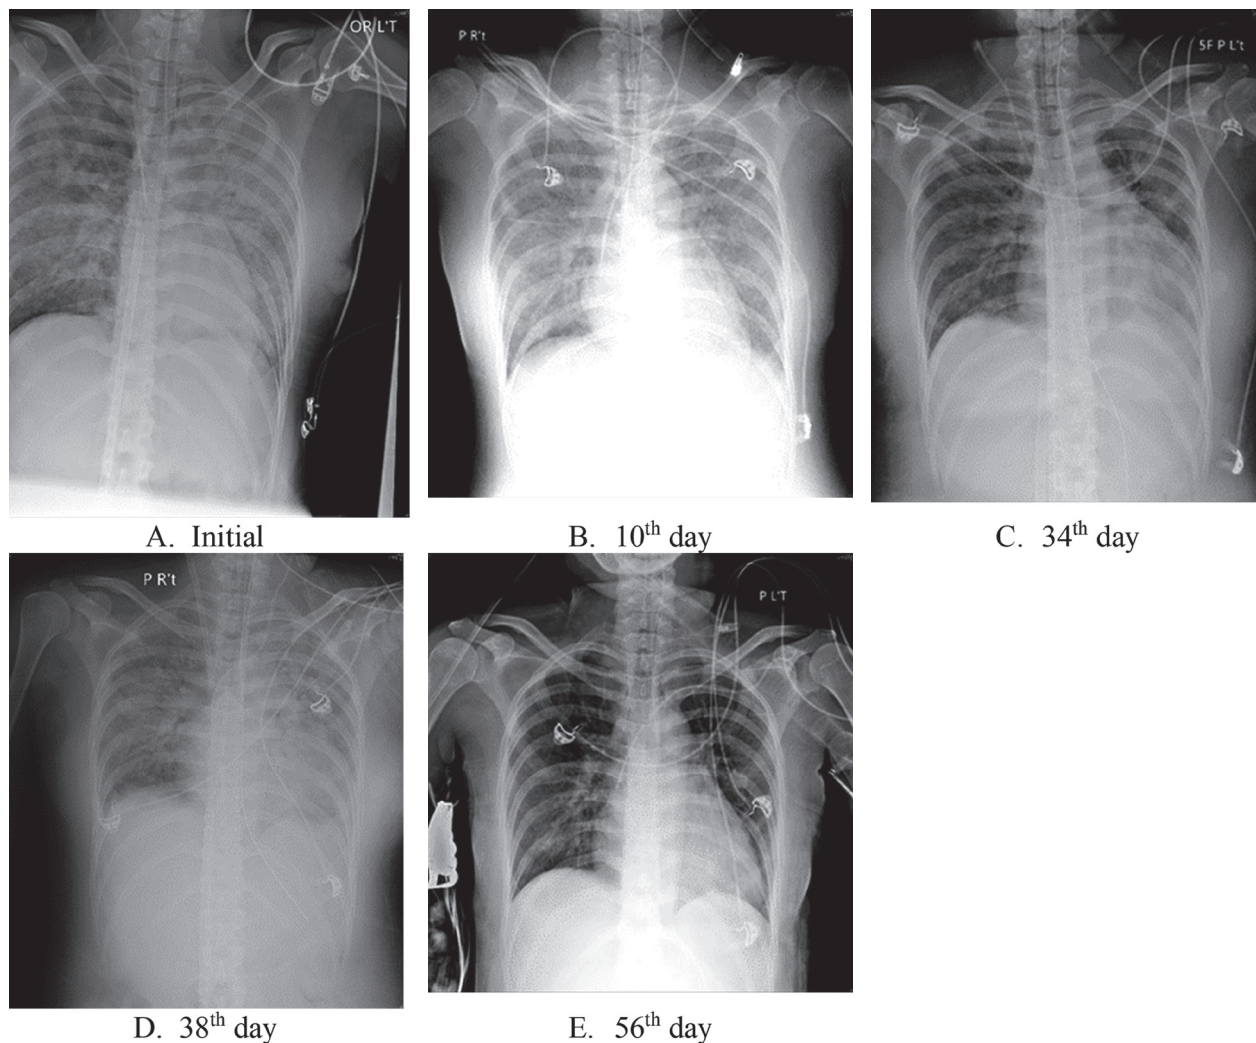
Chest radiograph.
